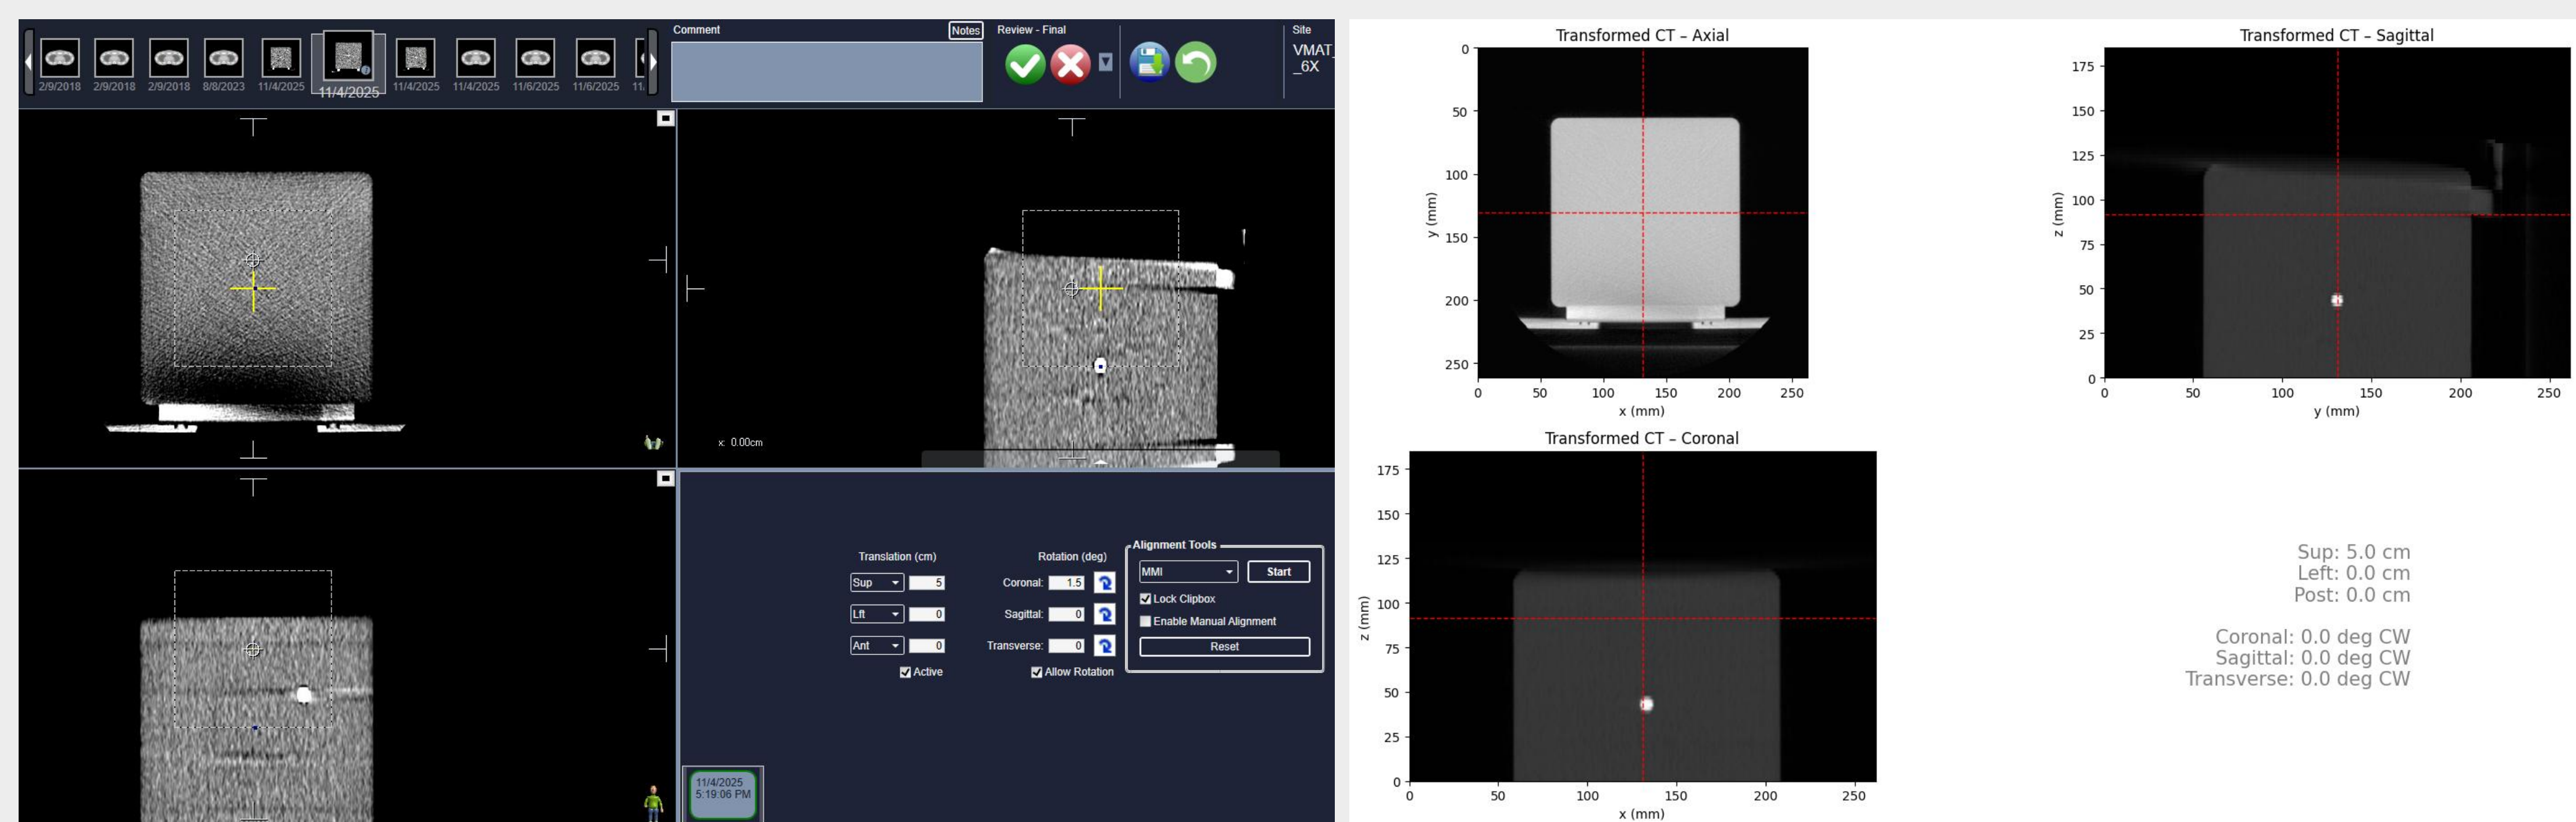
Validation of pseudo-matched image generation (5 cm superior shift with a tilted CBCT: 1.5-degree rotation)
